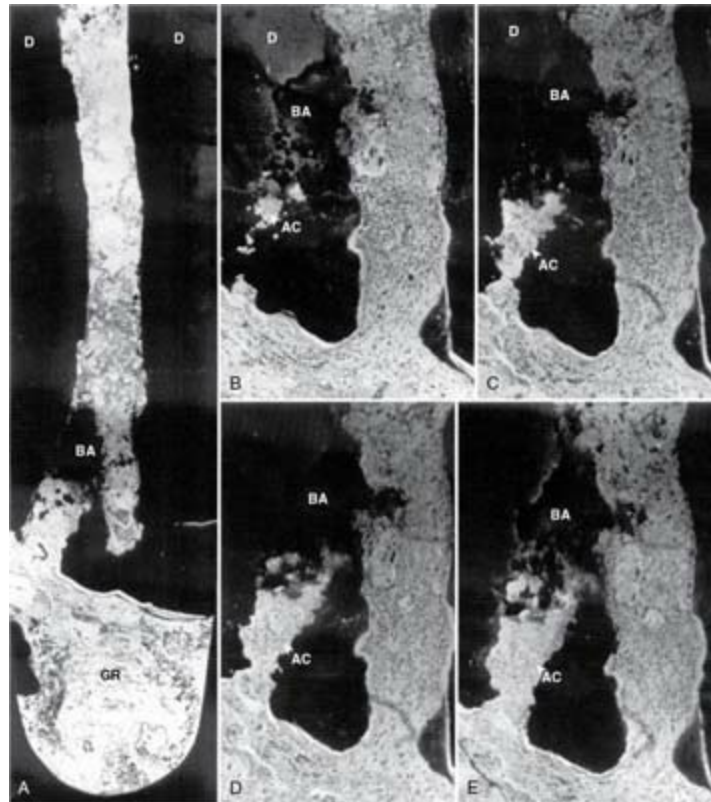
Axial sections through the surgically removed apical portion of the root with a therapy-resistant periapical lesion (*GR*). Note the cluster of bacteria (*BA*) visible in the root canal. Parts (B)–(E) show serial semithin sections taken at varying distances from the section plane of (A) to reveal the emerging (B) and gradually widening (C–E) profiles of an accessory root canal (*AC*). Note that the accessory canal is clogged with bacteria (*BA*). Original magnification: A, $\times 52$; B–E, $\times 62$.
